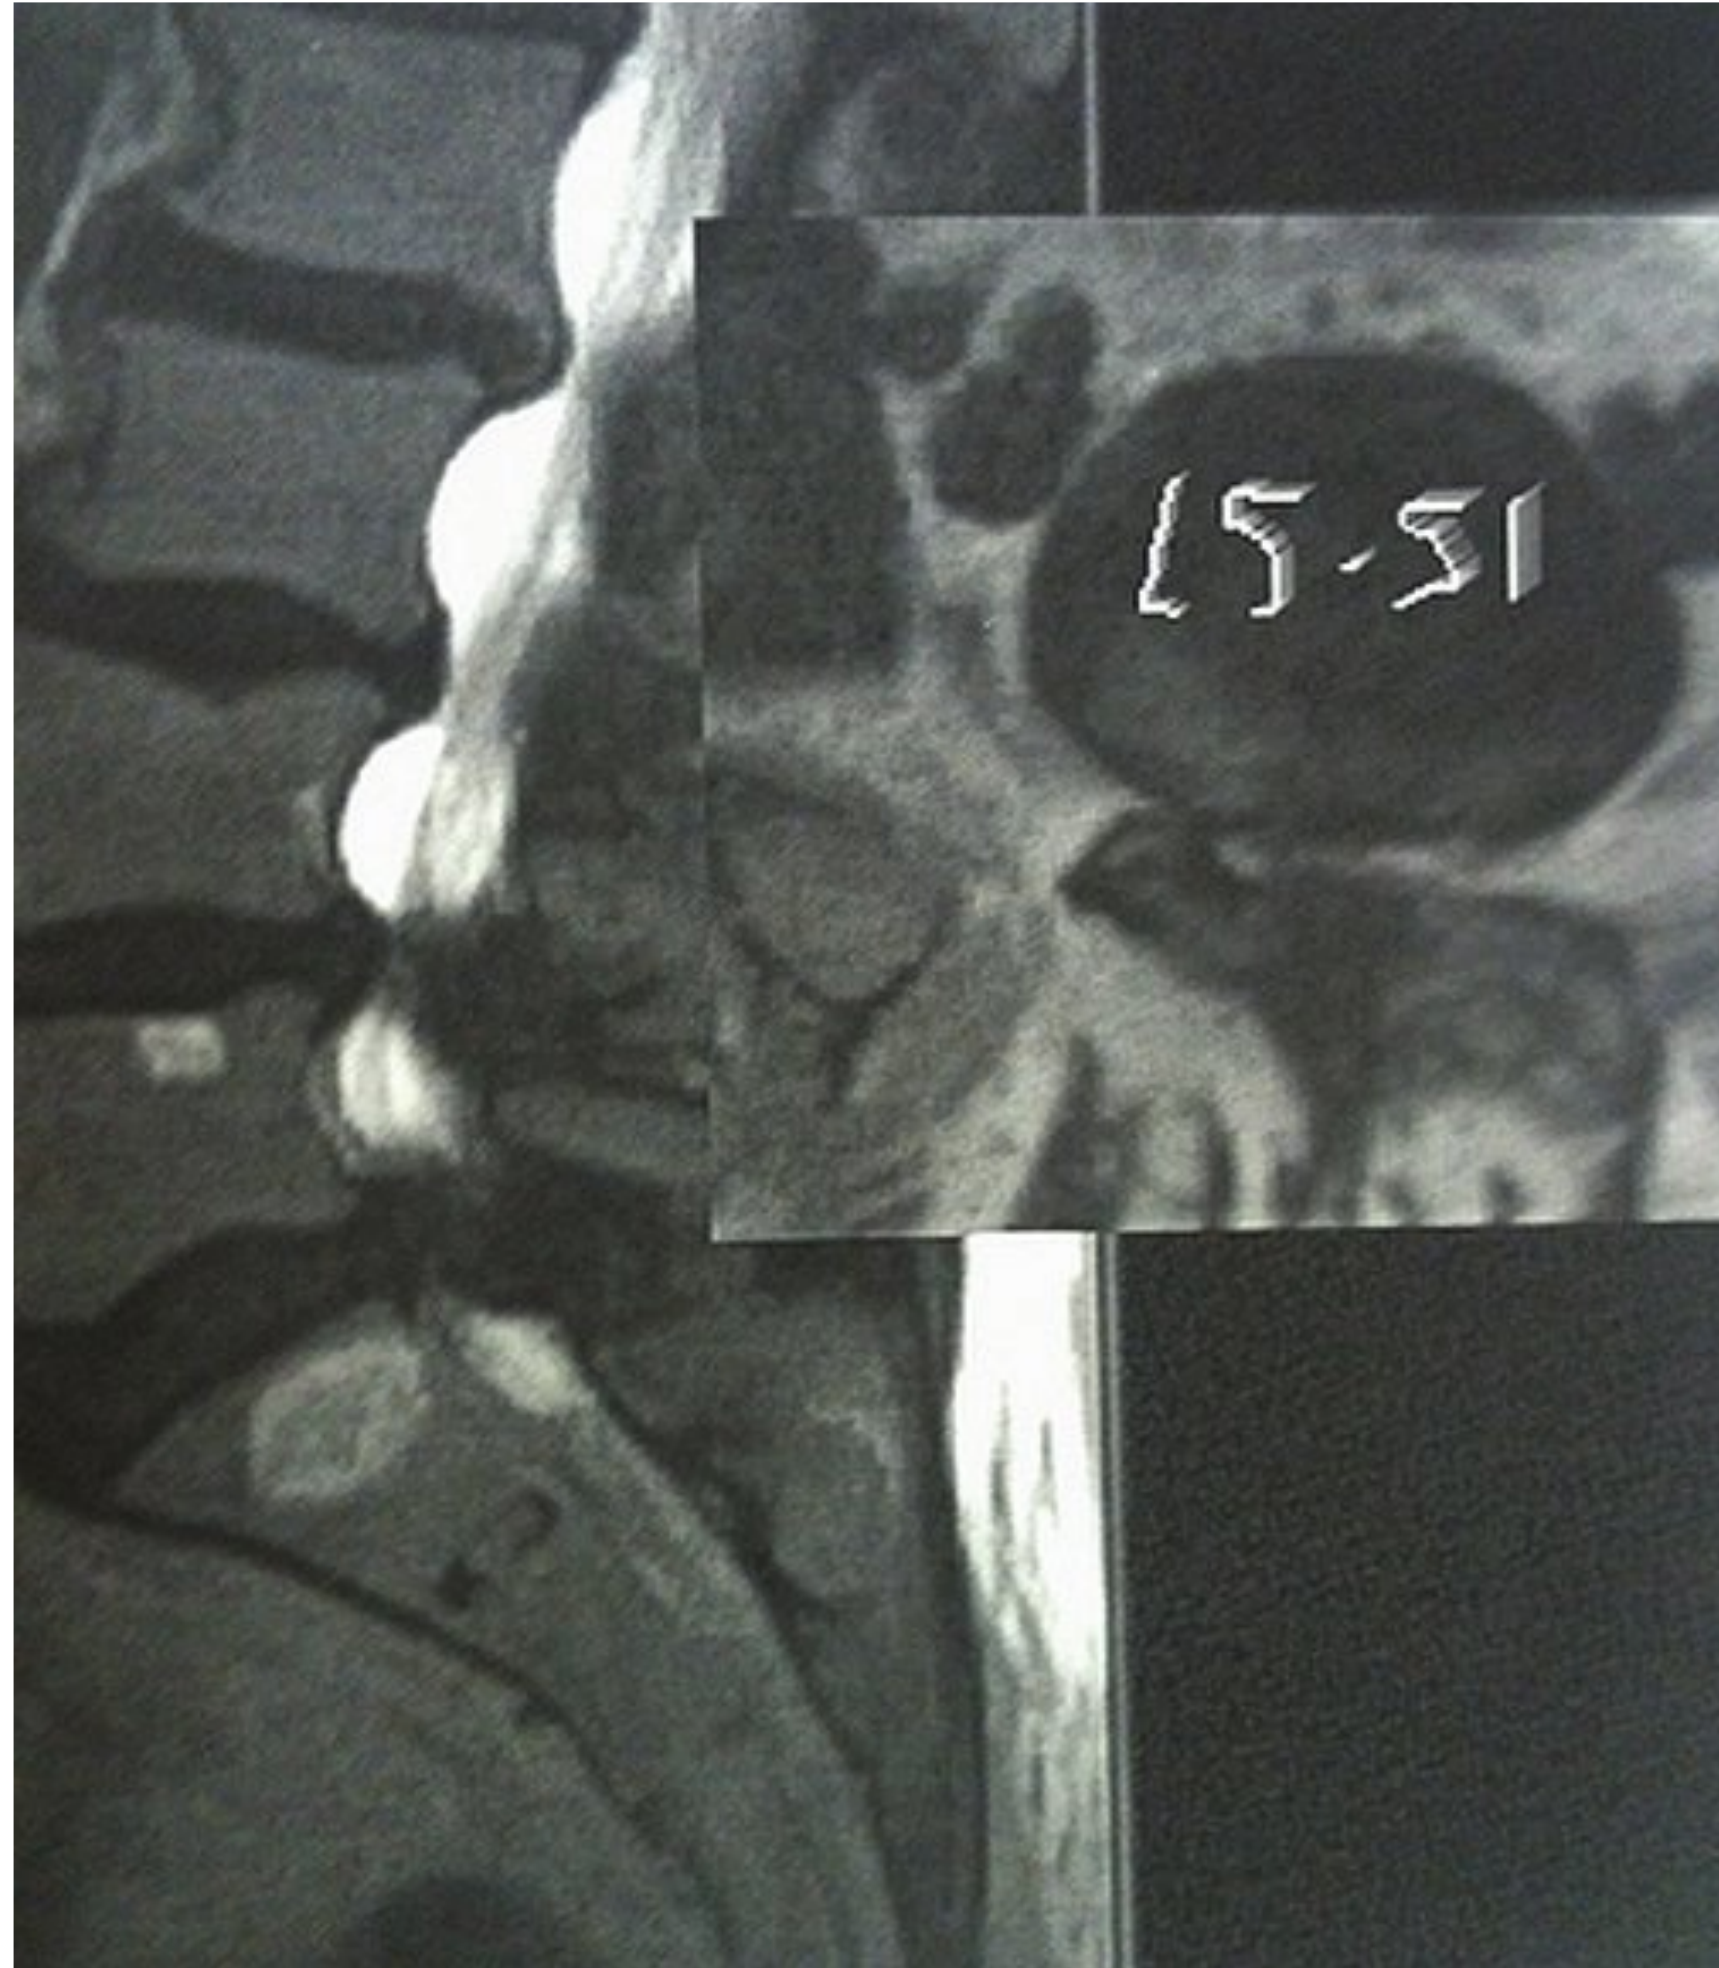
Lumbar T2-weighted MRI sagittal and axial images with severe stenosis at L5-S1.
